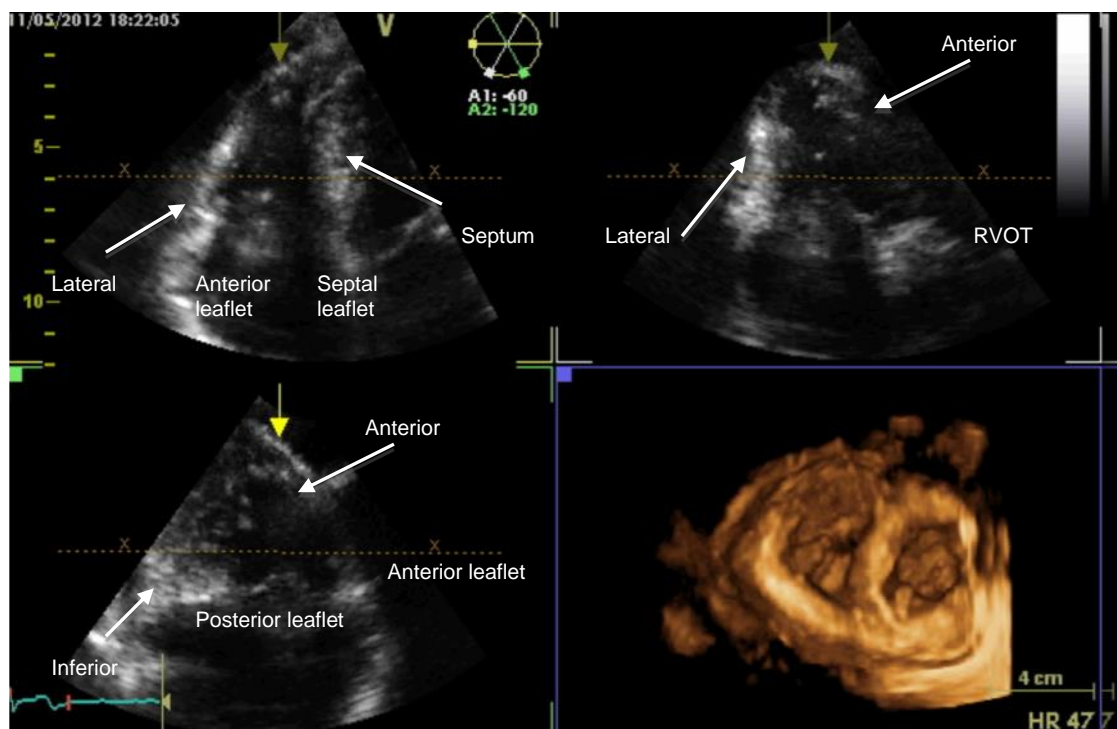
Transthoracic 3D assessment view acquired in the apical four chamber view using the 3D probe. The quad slice view allows assessment of each component of the RV in an alternative fashion to the standard 2D probe to allow the user to maximise endocardial definition. See section 1.17 for detailed explanation.
